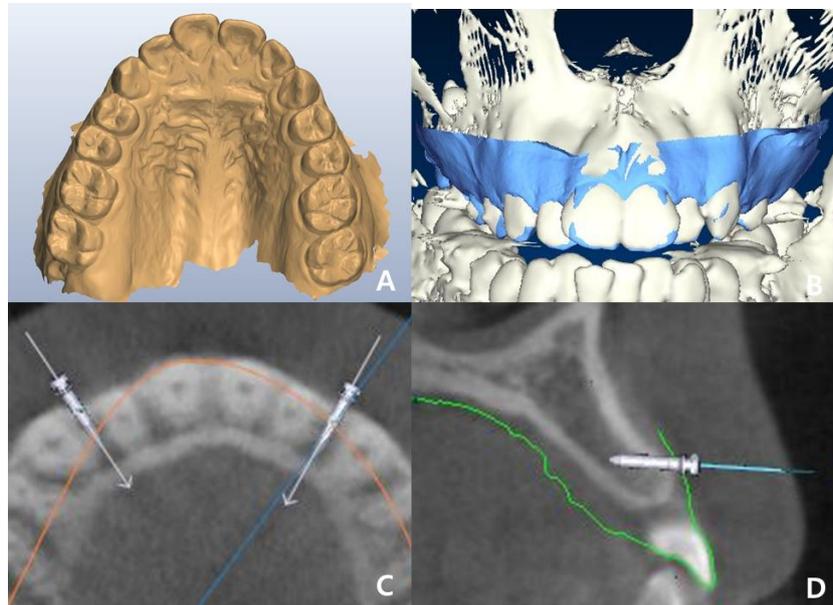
Planning procedure for miniscrew insertion: A, 3D digital model scanned with intra oral scanner; B, Merging of the CBCT and scanned model; C, Determination of site of miniscrew from axial views of reconstructed images; D, Determination of site of miniscrew from coronal views of reconstructed image.
